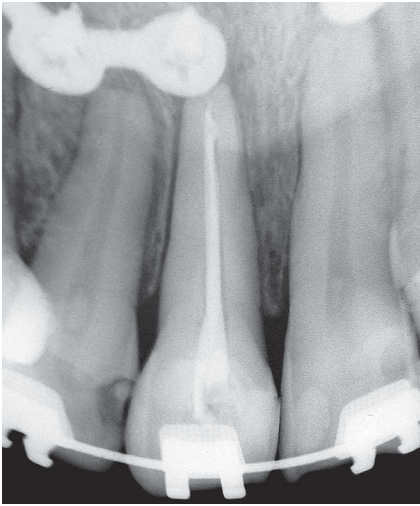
Preoperative periapical radiograph of tooth #21.
